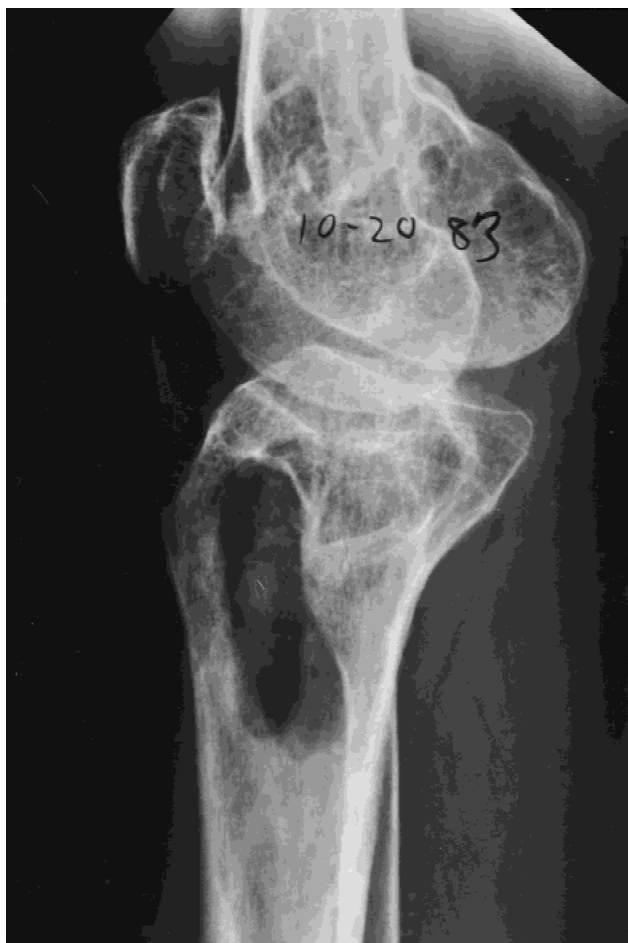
Lateral radiograph of a patient with osteomyelitis of proximal tibia. This shows wide debridement of the involved area.
